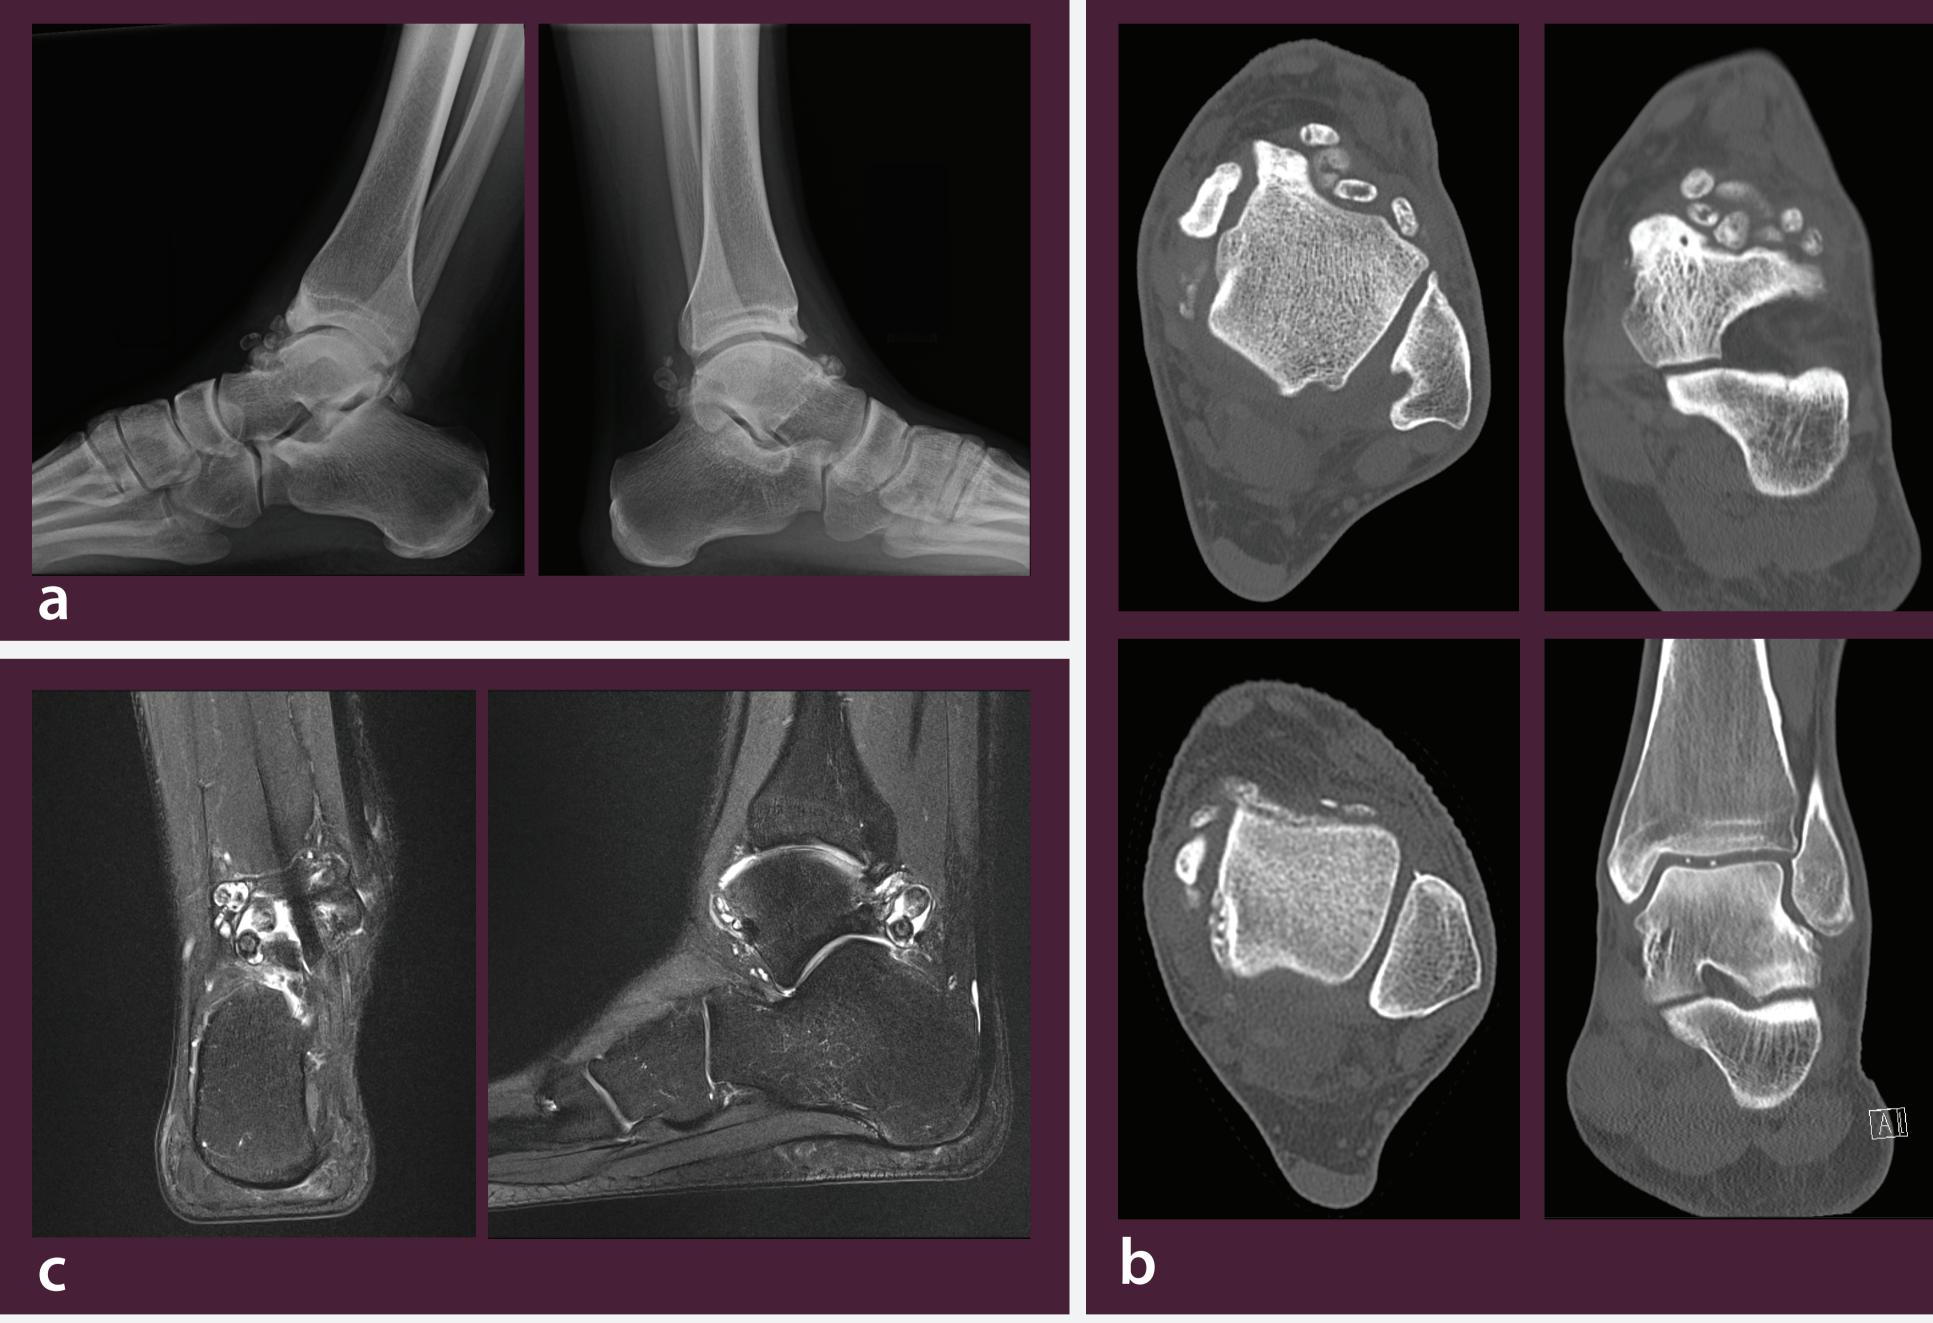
Imaging studies utilized pre-operatively included a) plain film radiographs in all cases, b) CT in two cases and c) MRI in a single case.
